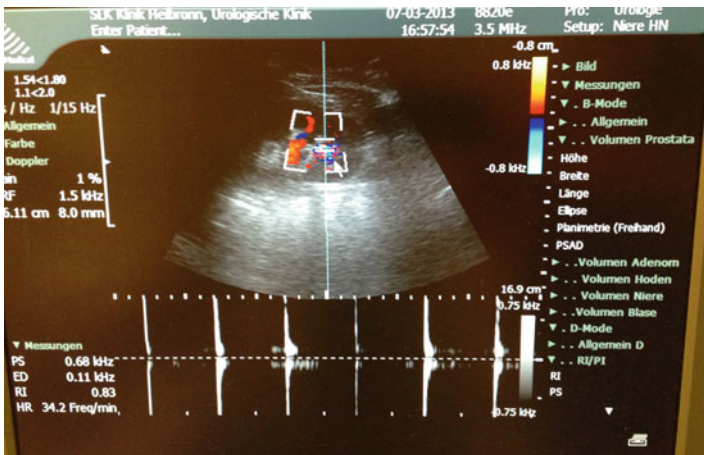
Use of color-coded duplex ultrasonography for localization of stones during ESWL. CCD signal indicates by sound and graphics when the stone is hit by the shock wave. Moreover, the change of the signal may indicate breakage of the stone (From Rassweiler et al. [36])
